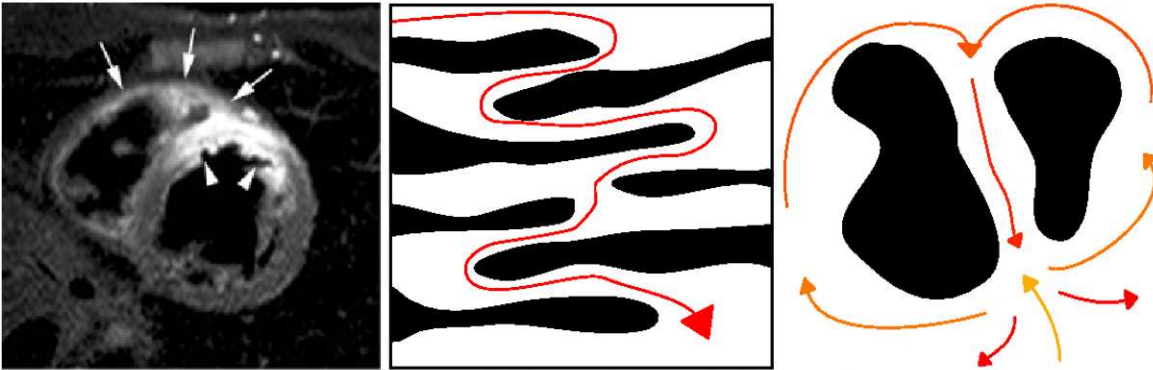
Myocardial infarction and diverted wave propagation. *Left* - MRI displays infarct in white. *Middle* - Path of activation wave (*red*) through surviving tracts of myocardium around fibrotic tissue (*black*). *Right* - Proposed circuit of propagation (*yellow to red*) around infarct scar (*black*).
